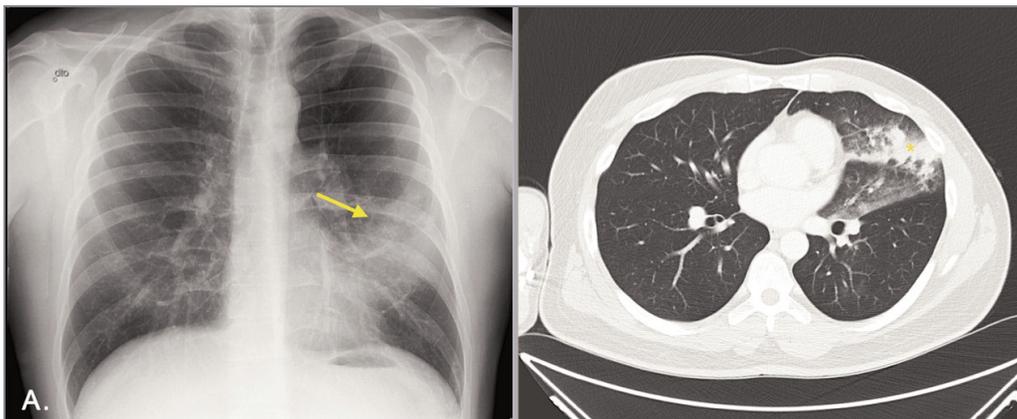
Case 3. A. Chest x-rays showing air space opacification of the left lung (arrow); B. CT scan showing lingual interstitial infiltrate (*).
